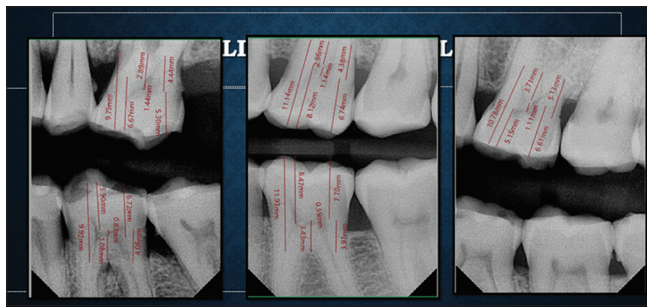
Bitewing radiograph of maxillary and mandibular molars showing measurements of various landmarks in the old population.
